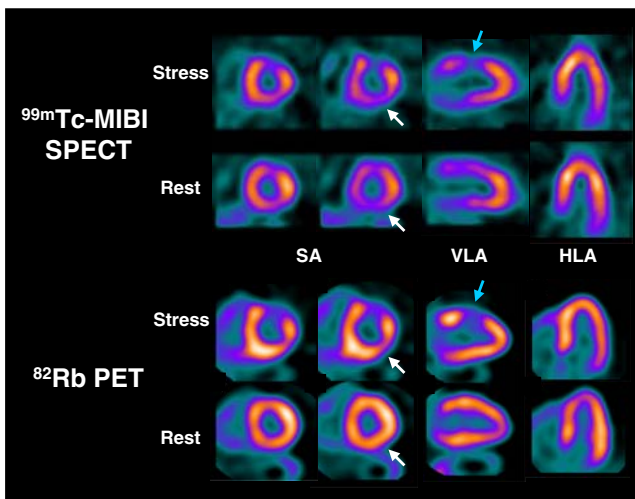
Myocardial perfusion SPECT (*top*) and PET (*bottom*) images in a patient with known triple vessel CAD, new onset of angina and a body mass index of 35 kg/m². PET shows reversibility in anterolateral (*blue arrows*) and inferolateral region (*white arrows*), confirmed by high-grade stenoses of first diagonal and left circumflex arteries at angiography. Note that inferolateral reversibility is difficult to discern on SPECT due to attenuation. SA Short axis, VLA vertical long axis, HLA horizontal long axis
